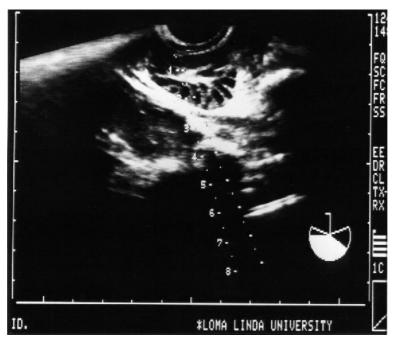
Representative ultrasonogram of a baboon ovary containing multiple follicles, just before aspiration
